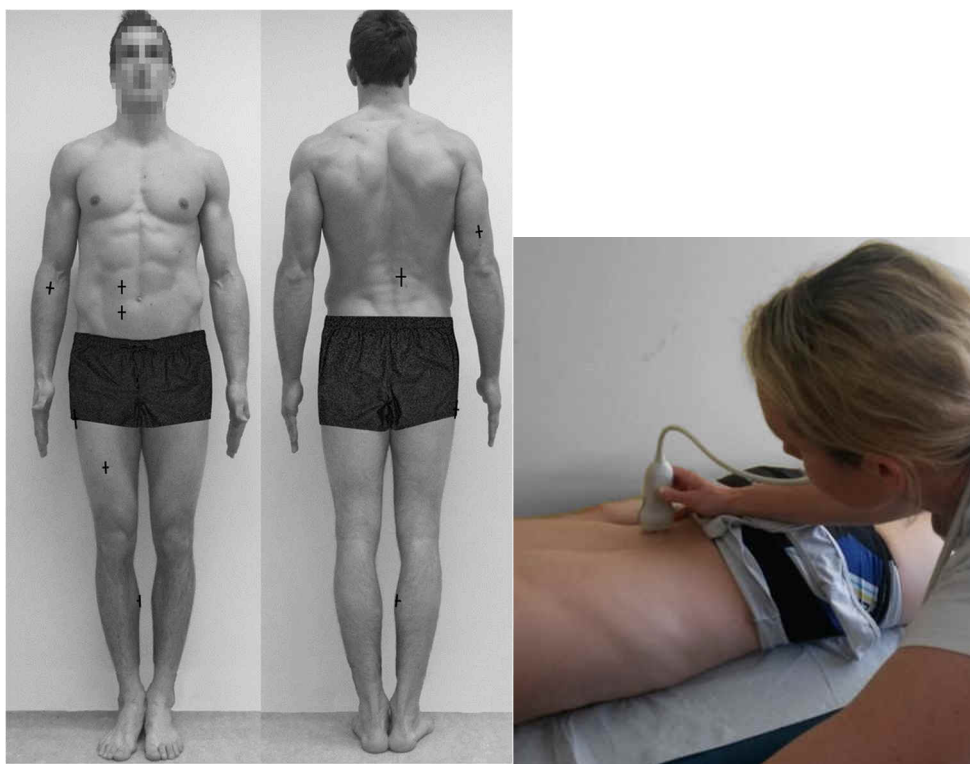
Landmarked eight body sites, and ultrasound imaging of the site erector spinae (ES).
